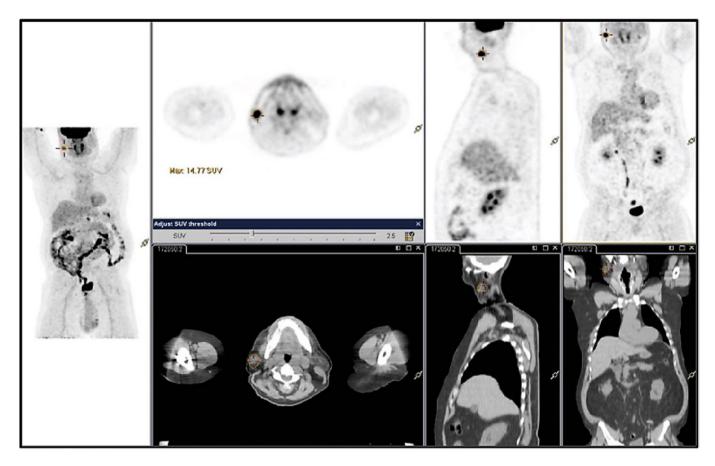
PET-CT images demonstrating transverse and coronal plane identifying high 18F-FDG (18F-fluorodeoxyglucose) uptake in right parotid lesion.
